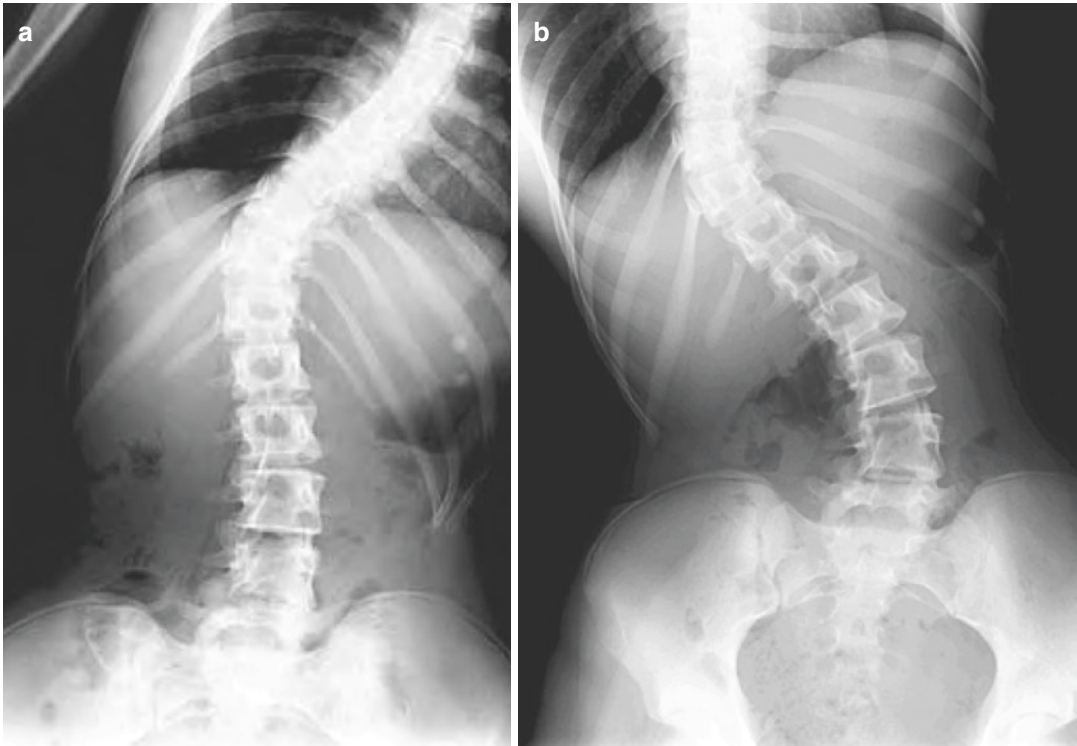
Lateral-bending radiographs: Figure a shows a patient bending to the left. Figure b shows the same patient bending to the right. The thoracic curve does not
